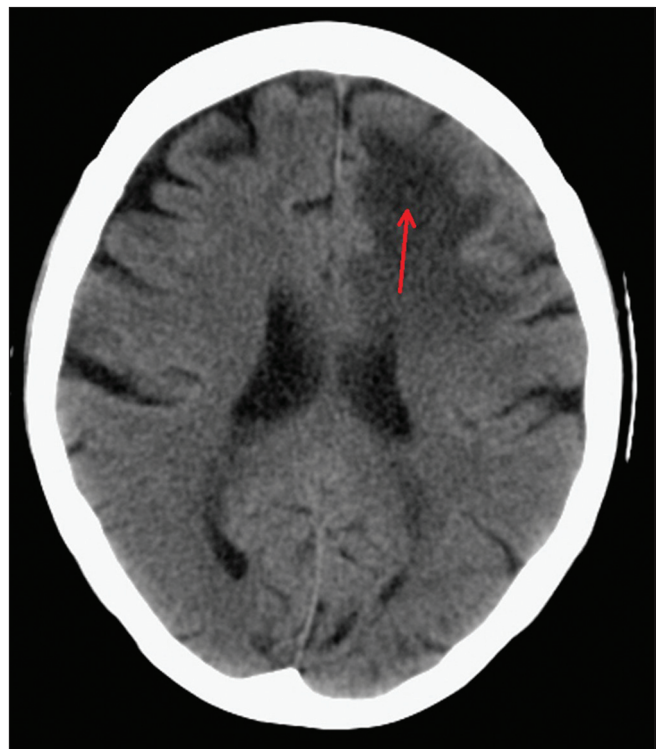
Computed tomogram brain showing a focal relatively hyperdense nodule (arrow) in the left frontal lobe white matter with extensive perilesional edema
